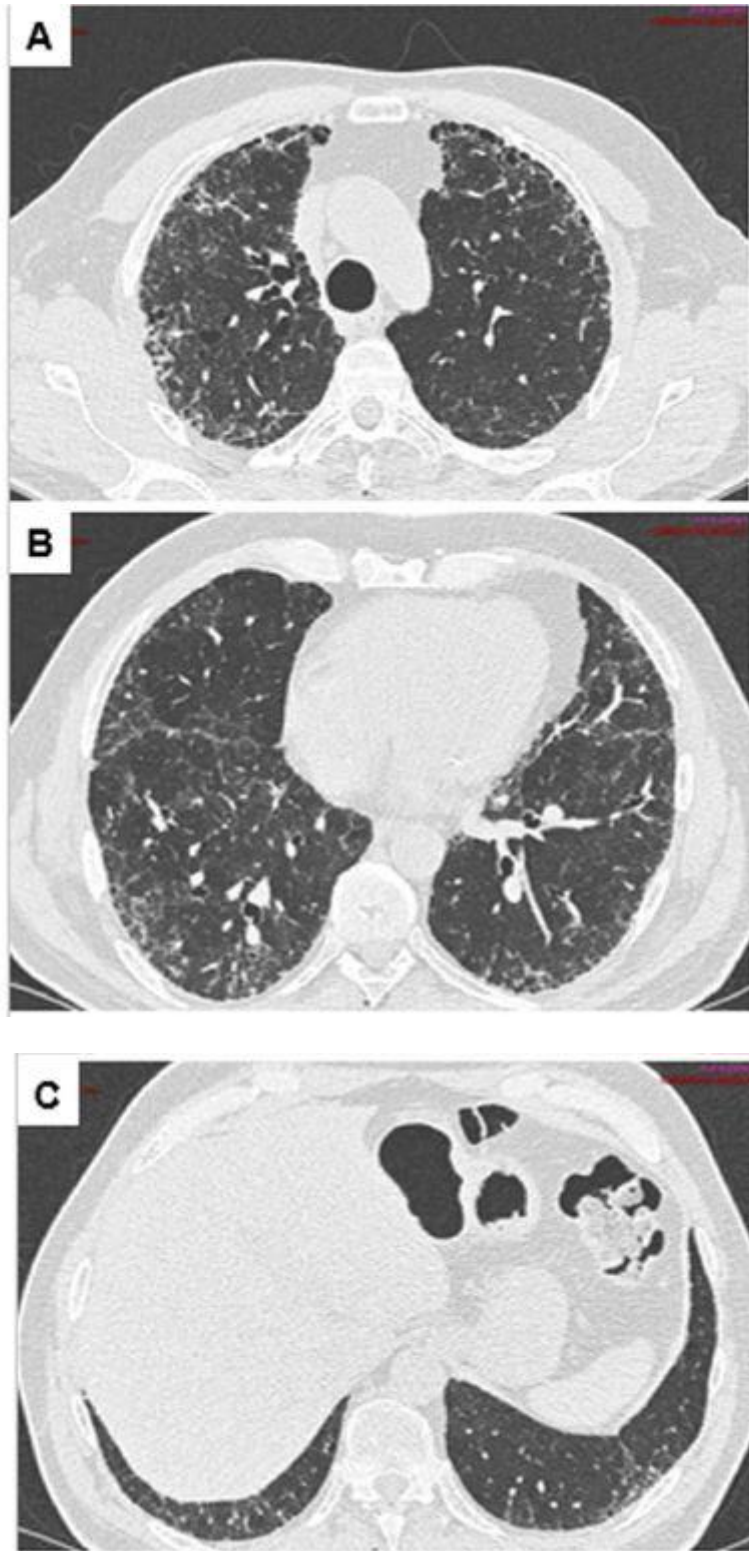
Indeterminate for usual interstitial pneumonia (UIP) pattern on the CT scan. Presence of reticular opacities and traction bronchiectasis, absence of honeycombing. The lesions are not distributed as in UIP (absence of apico-basal gradient).
